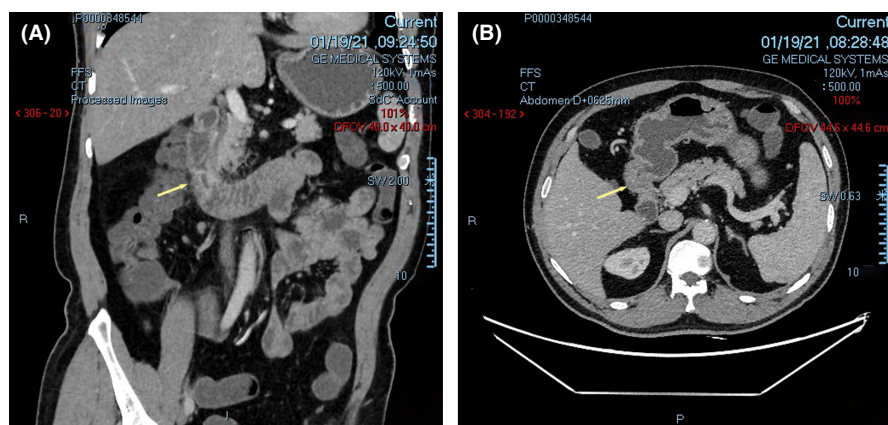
Plain abdominal CT scan revealed lesion of the descending duodenum (yellow arrow). (A) Coronal plane view. (B) Horizontal plane view.
